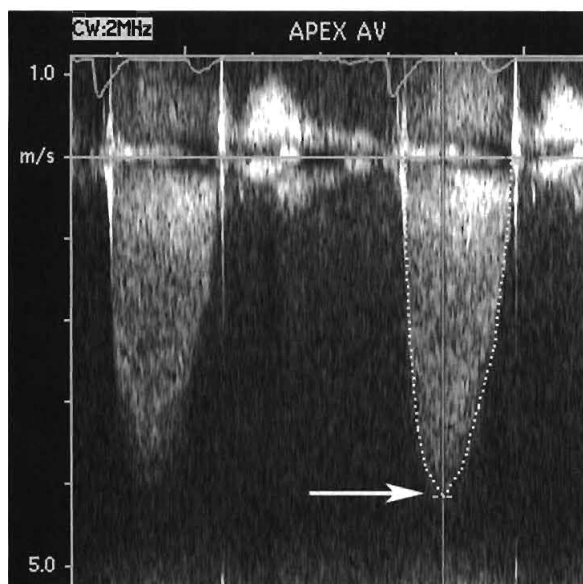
Continuous wave Doppler examination of the aortic valve in the patient shown in Figure 103-10 demonstrates a high-velocity signal consistent with severe aortic stenosis. The maximum velocity of 4.2 m/s corresponds to a maximum transaortic pressure gradient of 69 mm Hg and a mean gradient of 41 mm Hg. Valve area, calculated by the continuity equation, was 0.8 cm².
